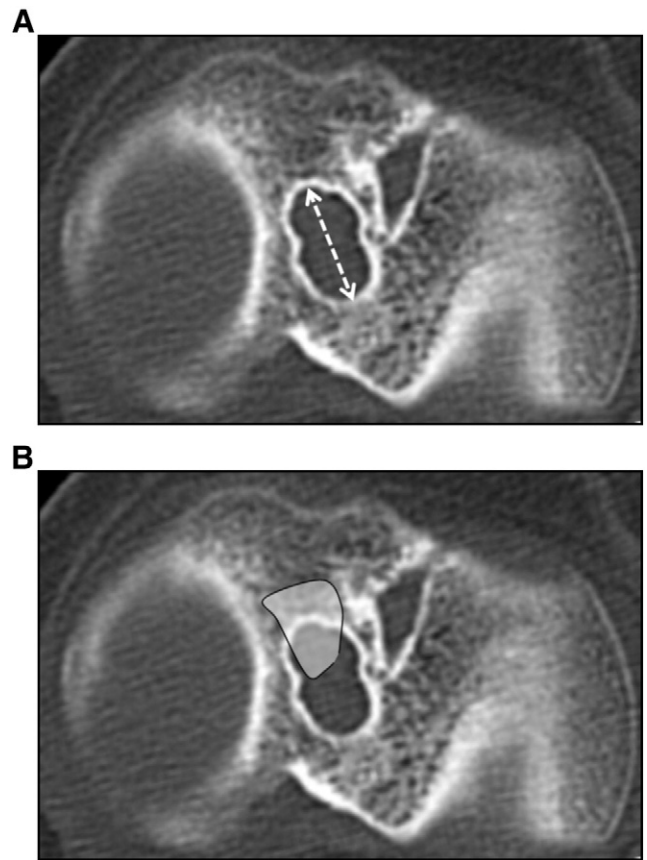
Evaluation of tibial tunnel aperture by CT imaging of the articular surface as an indication of iliac bone grafting.
